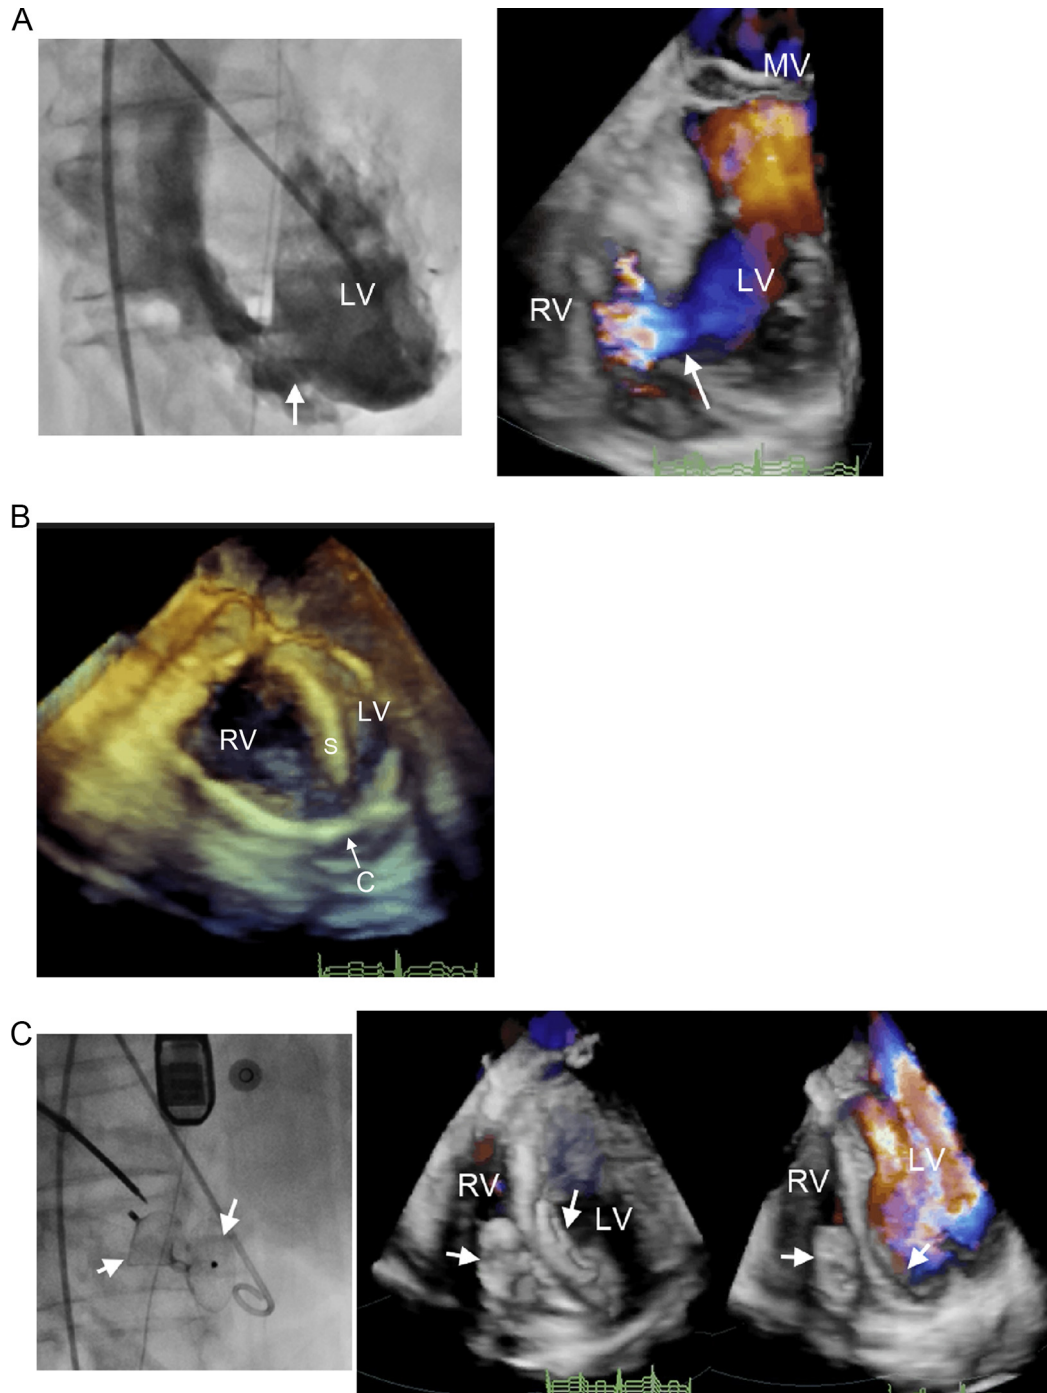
(A) Left ventricle angiogram (left frame) and 3D TEE with color flow Doppler (right frame) demonstrating an 8-mm defect at the apical interventricular septum (arrow). A shunt into the right ventricular cavity was noted. (B) 3D TEE demonstrating a 9-French delivery sheath (C) successfully passed through the defect of PIVSD. S = interventricular septum. (C) Fluoroscopic image (left frame) and 3D TEE with color flow Doppler (middle frame) demonstrating a cribriform septal occluder (arrow) successfully deployed at the proper position and without shunt (right frame). 3D = three-dimensional; MV = mitral valve; LV = left ventricle; RV = right ventricle; TEE = transesophageal echocardiography.
